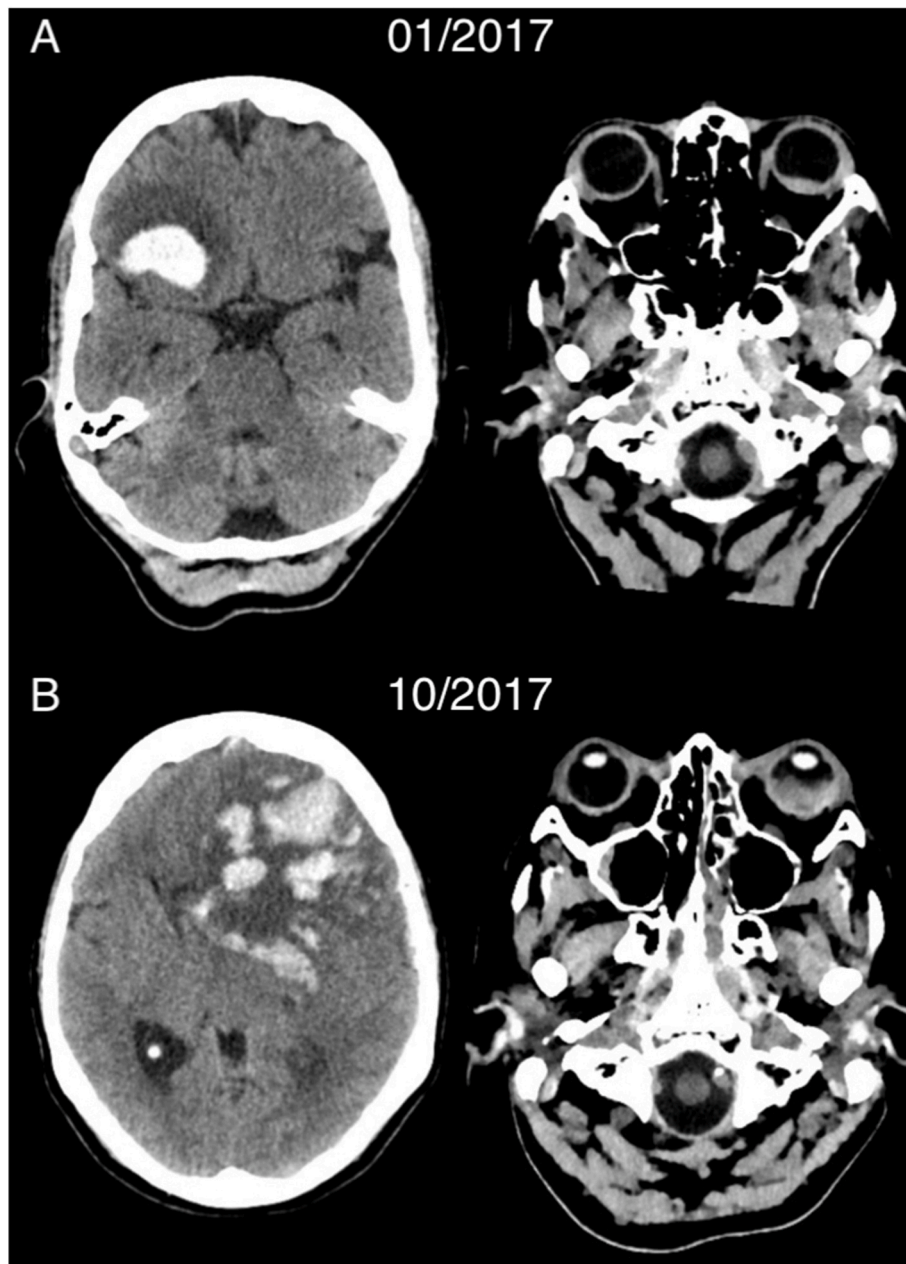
Axial brain CT scans showing the two episodes of intracranial hemorrhage A) A right frontal lobe hematoma with surrounding intracerebral edema. B) Massive intracranial hemorrhage involving mainly the left frontal lobe with surrounding intracerebral edema and midline shift. Vitreous hemorrhage was noted in the left eye on both occasions.
